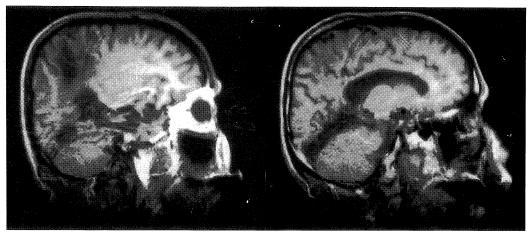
MR imaging (T1) shows the lesion of parietal lobe and occipital lobe of right hemisphere.
